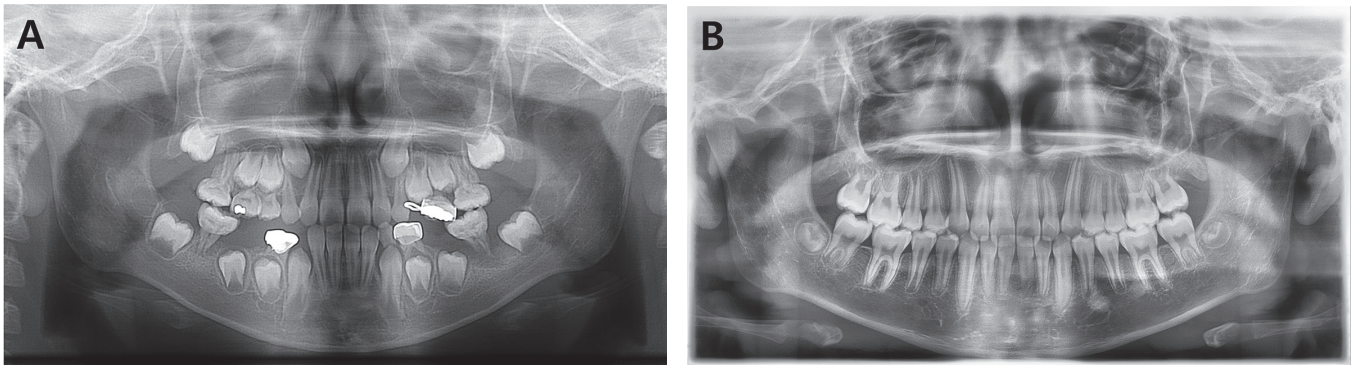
Radiographs of patient 2 and her twin sister. (A) Initial panoramic view of patient 2 shows short and twined roots of permanent first molars. (B) Panoramic radiograph of her twin sister shows normal occlusion.
